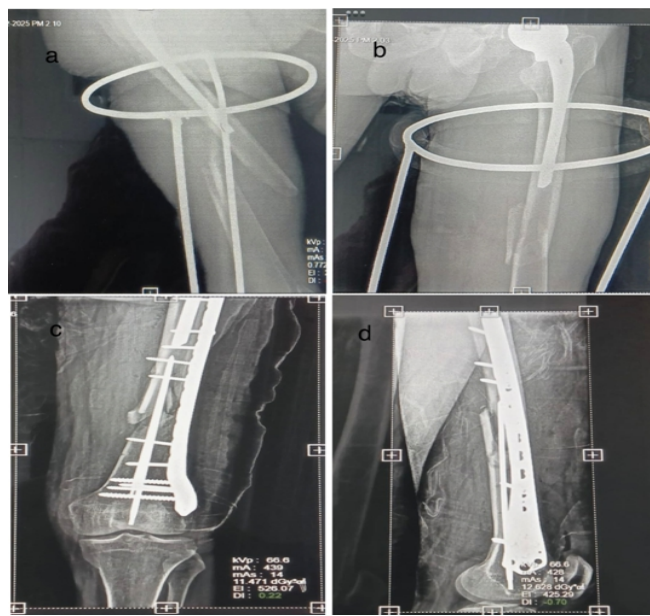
(a and b) pre-operative X-rays; (c and d) post-operative X-rays.
